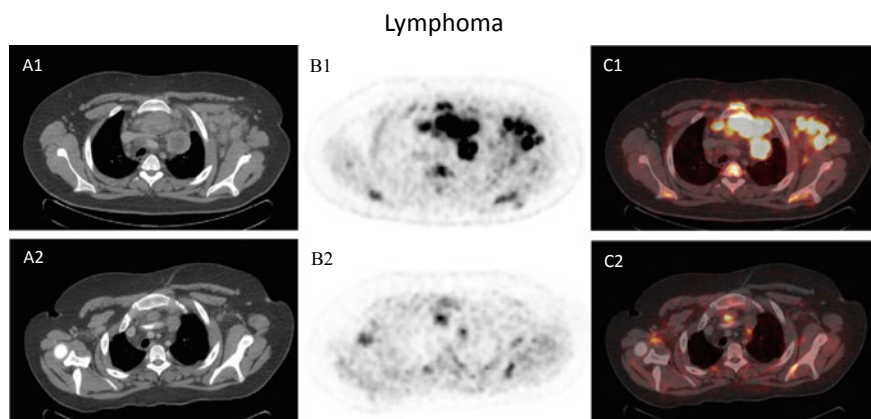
19-year old male patient with Hodgkin lymphoma, referred to FDG PET/CT for initial staging (August 2015; images A1/B1/C1) and for re-staging (January 2016; images A2/B2/C2) after chemotherapy (6 cycles of BEACOPP August-December 2015). Initial FDG PET/CT showed manifestations of lymphoma on both sites of the diaphragm (Ann Arbor stage III), FDG PET/CT after chemotherapy showed vital lymphoma residuals in the mediastinum (visually Cheson/Deauville score 3–4, which means $>$ mediastinal blood pool uptake, but \leq liver uptake and moderately above liver uptake, respectively). As a consequence the patient was referred to adjuvant radiotherapy; (A1-2) CT-Scan, (B1-2) PET scan, (C1-2) PET/CT fused images
